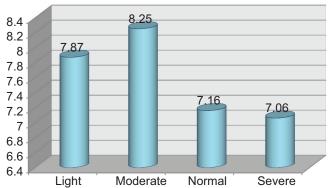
Mean value of hemoglobin based on MRI T2 grading
